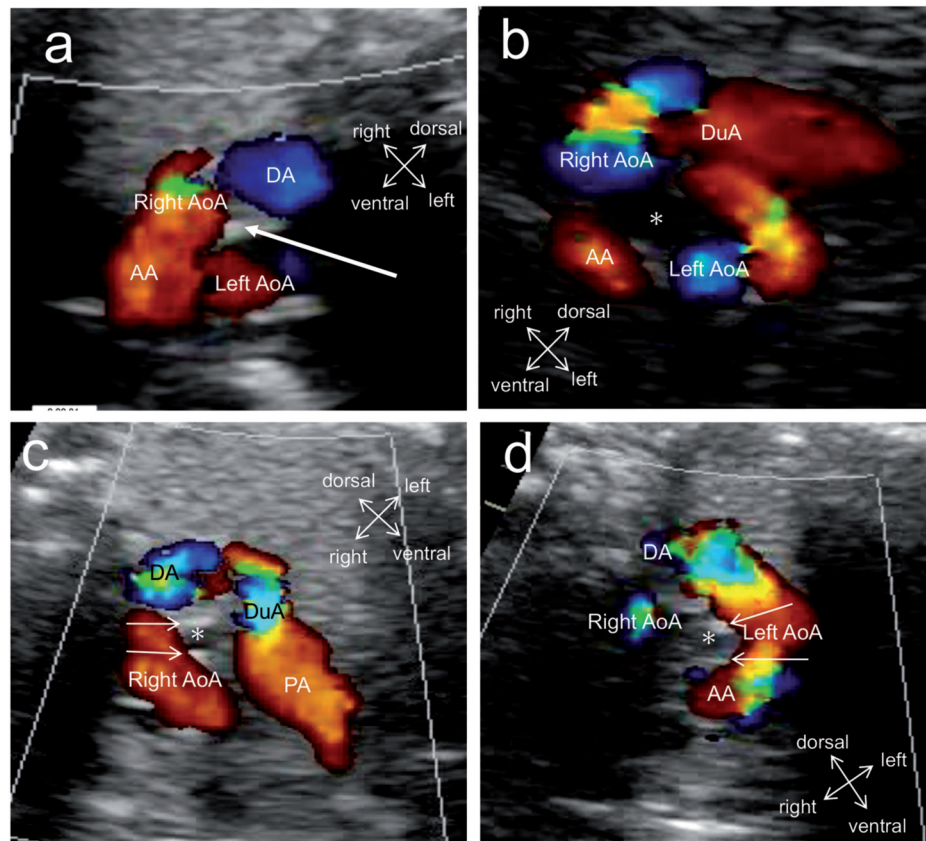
Fetal ultrasound findings indicative of tracheal stenosis + vs. —.
